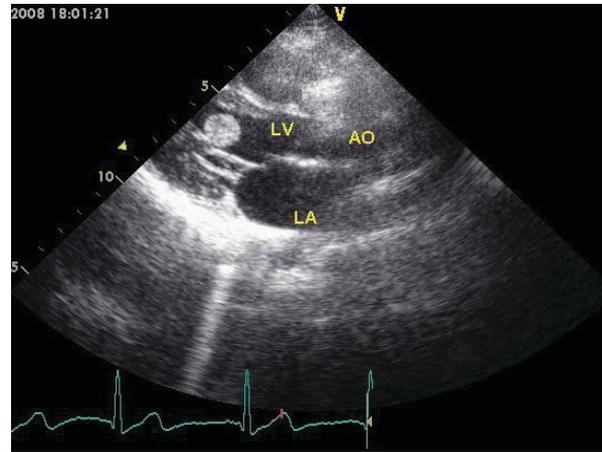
Arrowhead shows left ventricular mass in parasternal short axis view.
